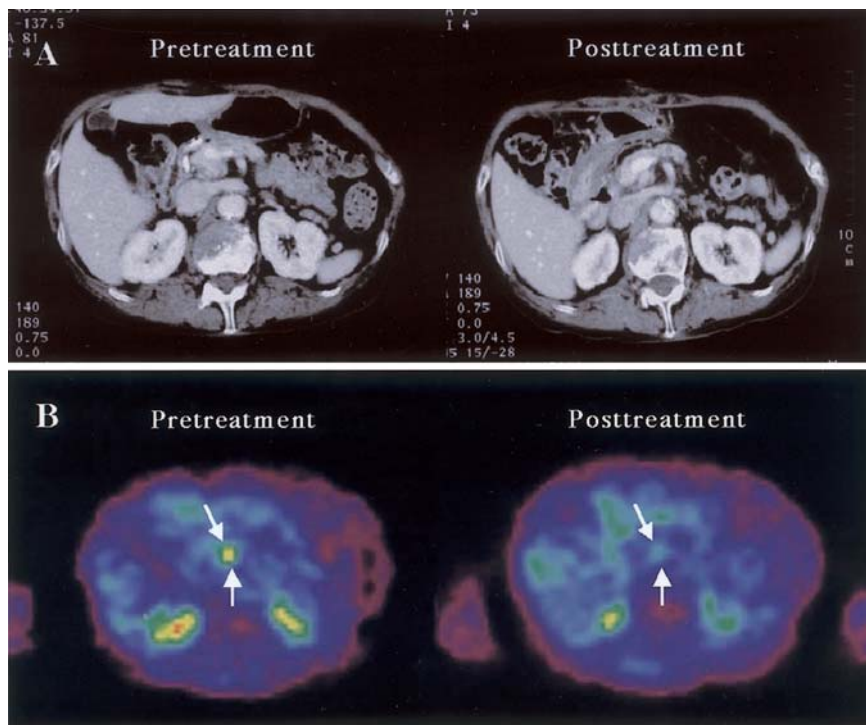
Diagnostic images of patient 7, as a representative of category II. A Computed tomography (CT) scan does not show the tumor in the pancreatic head accurately, so changes in tumor size cannot be tracked in the posttreatment stage. B Pretreatment PET image shows increased FDG uptake in the pancreatic head (*arrows*); uptake is clearly reduced in the posttreatment stage
